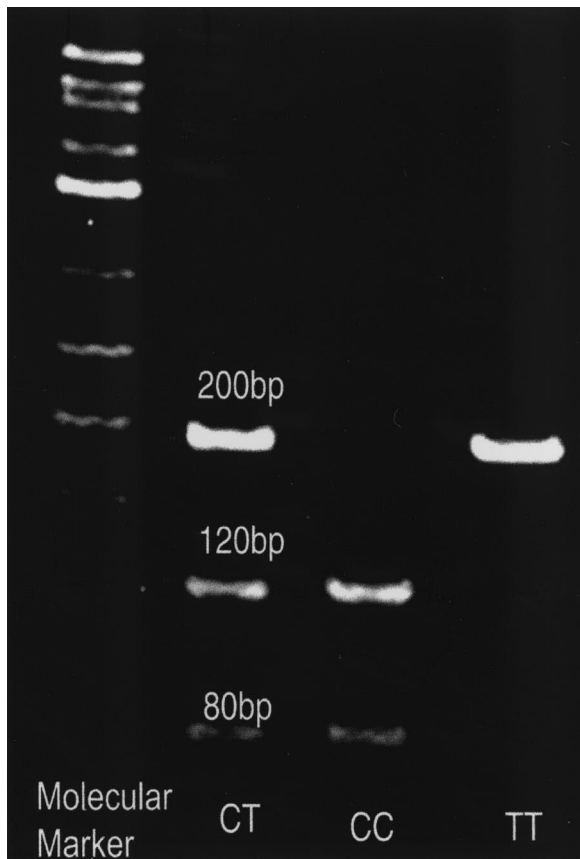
The PAGE gel shows the PCR products from the amplification of the mutation region of the PPARγ gene. The mutation eliminates a *PmlI* recognition site which digests the 200 bp PCR fragment into 120 and 80 bp fragments. Lane 1 is the molecular marker (Promega, φx174 DNA/*Hinf* I), lane 2 is a CT heterozygote, lane 3 shows a common CC homozygote, lane 4 is a rare TT homozygote.
